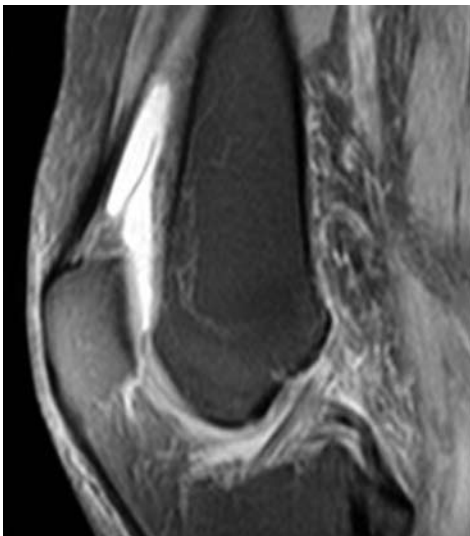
Sagittal fat-suppressed T2-W MR image of the right knee in a 42-year-old woman shows mild joint effusion and suprapatellar plica.
